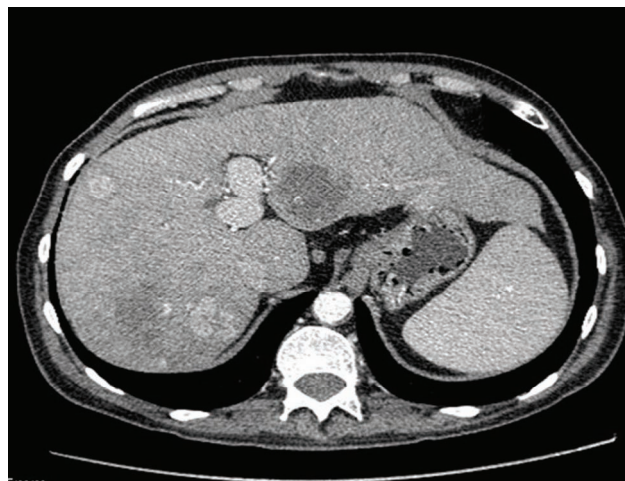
Multislice computed tomography shows two large focal lesions in the IV and VII segment of the liver.
